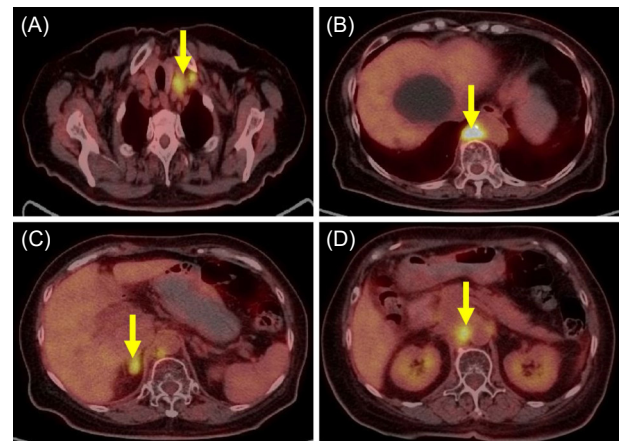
Pre-treatment PET-CT scans showing multiple metastatic sites at the time of disease progression in January 2021.
